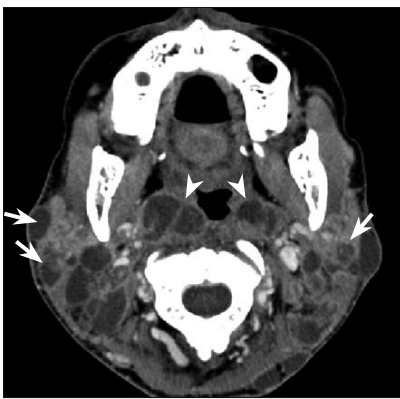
CT image of the upper neck shows innumerable pathologic, enlarged, low-density lymph nodes, which are characteristic (but not pathognomonic) for tuberculosis. Every nodal chain is involved, including retropharyngeal (*arrowheads*) and intraparotid (*arrows*) nodes.
